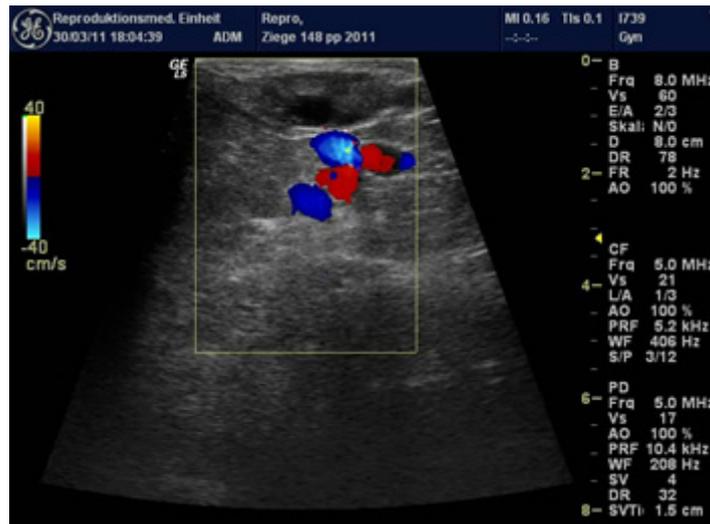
Blood flow in vessels detected by color Doppler mode. Red shows blood flow moving toward the ultrasound probe and blue shows blood flow moving away from it.
